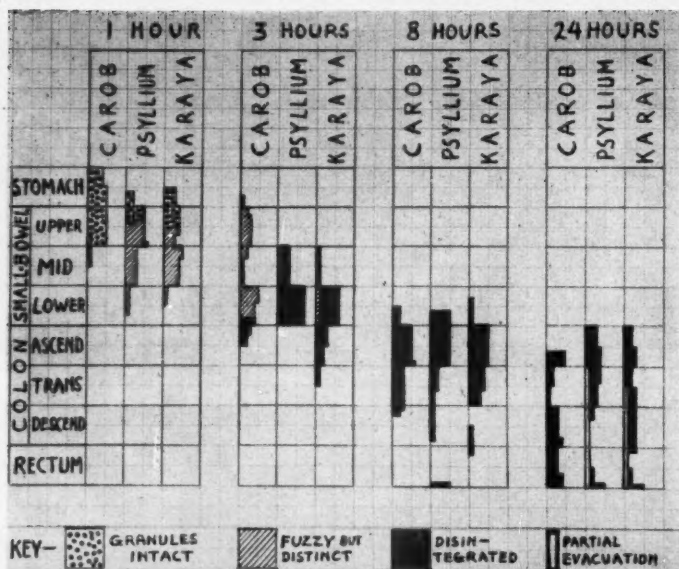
A graphic representation of the results of x-ray studies made on 10 individuals who took 3 special gum preparations by mouth.
